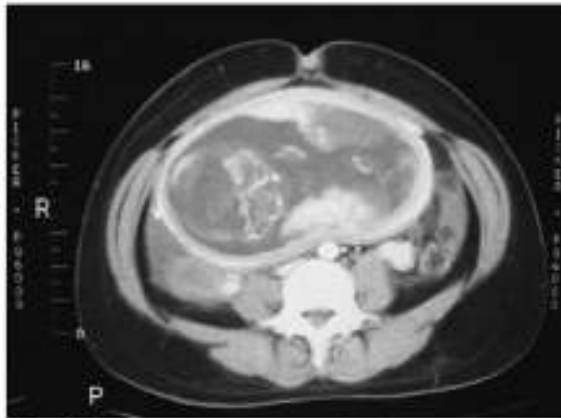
Computed tomography scan showing pregnant uterus above the level of umbilicus indicating a viable fetus.
